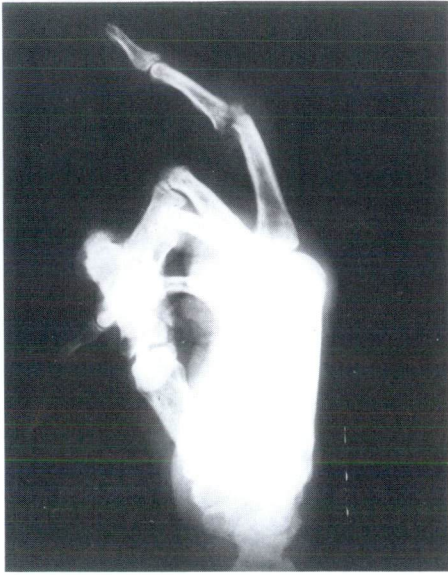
Two month post-operative lateral radiograph demonstrating adequate position of the silastic interpositional arthroplasty of the proximal interphalangeal joint, right middle finger.
